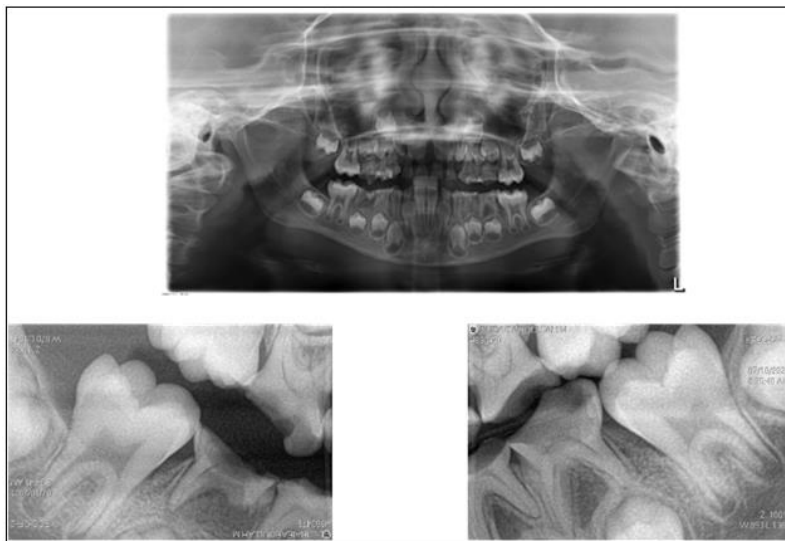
Panoramic and bitewings radiographs show multiple carious teeth; dental age coincides with chronological age.
